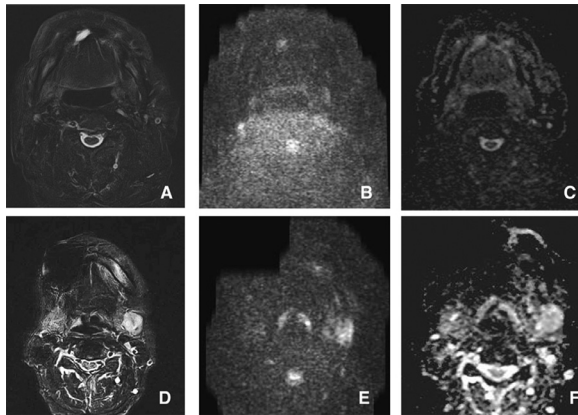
The MRI findings of a hemangioma (A, B, C) and a pleomorphic adenoma (D, E, F) as benign tumors representing lesions that may have cyst-like components other than ranulas on STIR (A, D), DWI (B, E), and the ADC map (C, F). The hemangiomas showed heterogeneous high signal intensity (A, B). The ADC map of the hemangioma (C) with an ADC value of $2.24 \times 10^{-3} \text{ mm}^2/\text{s}$ was relatively similar to ranulas. No significant differences were found in ADC values between hemangiomas and ranulas. Pleomorphic adenomas had heterogeneous high signal intensity on STIR and DWI (D, E). The ADC map of the pleomorphic adenoma (F) had a value of $1.35 \times 10^{-3} \text{ mm}^2/\text{s}$, lower than that of ranulas, although no significant differences were found in ADC values between these lesions. *ADC*, apparent diffusion coefficient; *DWI*, diffusion-weighted imaging; *MRI*, magnetic resonance imaging; *STIR*, short-T1 inversion recovery.
